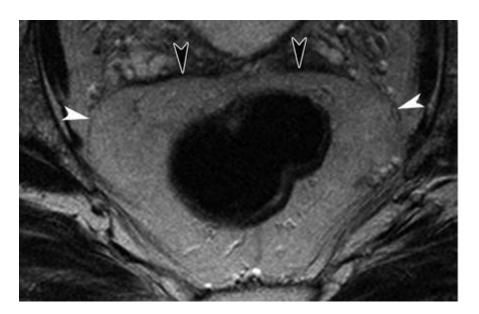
MRI axial image: Normal anatomy of mesorectum. Mesorectal fascia is shown as hypointense layer (white arrowheads) surrounding hyperintense mesorectal fat. Meosrectal fat is more abundant posteriorly than anteriorly (black arrowheads). Adapted from Lafrate et al., (2006)
